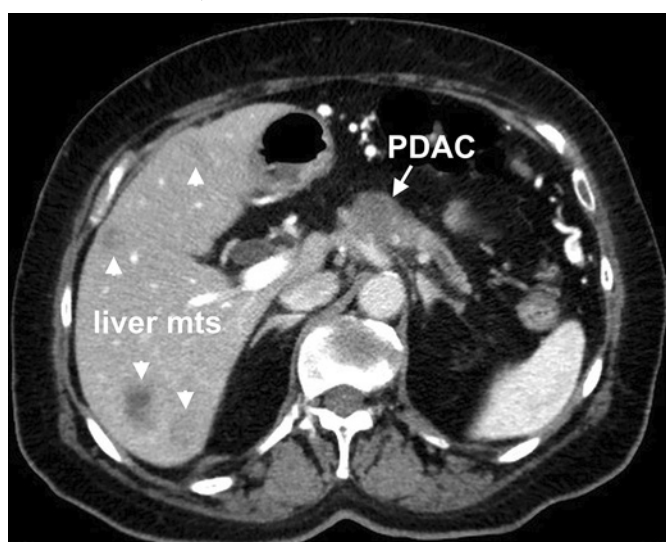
CT scan of generalized pancreatic ductal adenocarcinoma (PDAC) of the pancreatic body with liver metastases (arrowheads)
